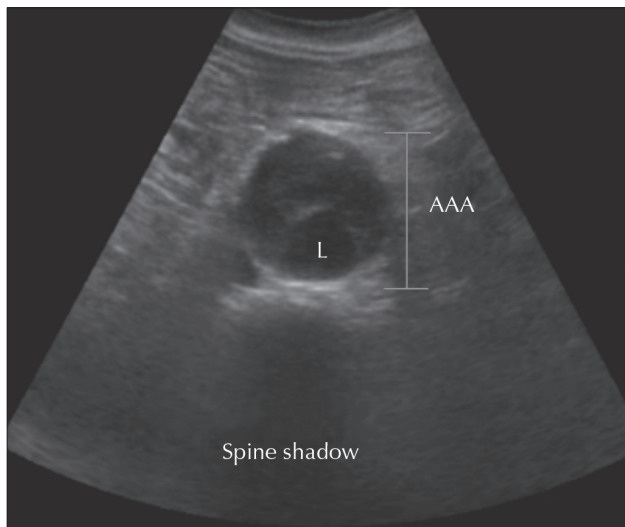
Ultrasonography image showing the lumen of the abdominal aorta (L) and extent of the abdominal aortic aneurysm (AAA). The spine shadow is the key landmark and represents an artifact produced by the vertebral body.
